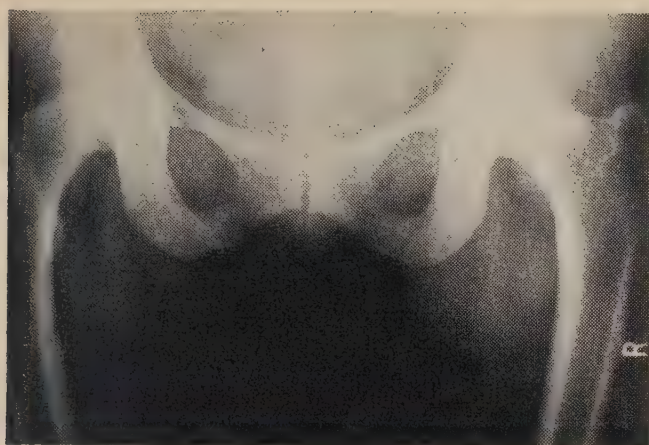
Radiographs of the skull, pelvis, forearm and leg. Note 'cyst-like' circumscribed radiolucent areas in the cranial vault; lesion in the ischium of the pelvis; radiolucent lesion in the radius of the forearm; and large radiolucent areas in the tibia (almost a fracture).
